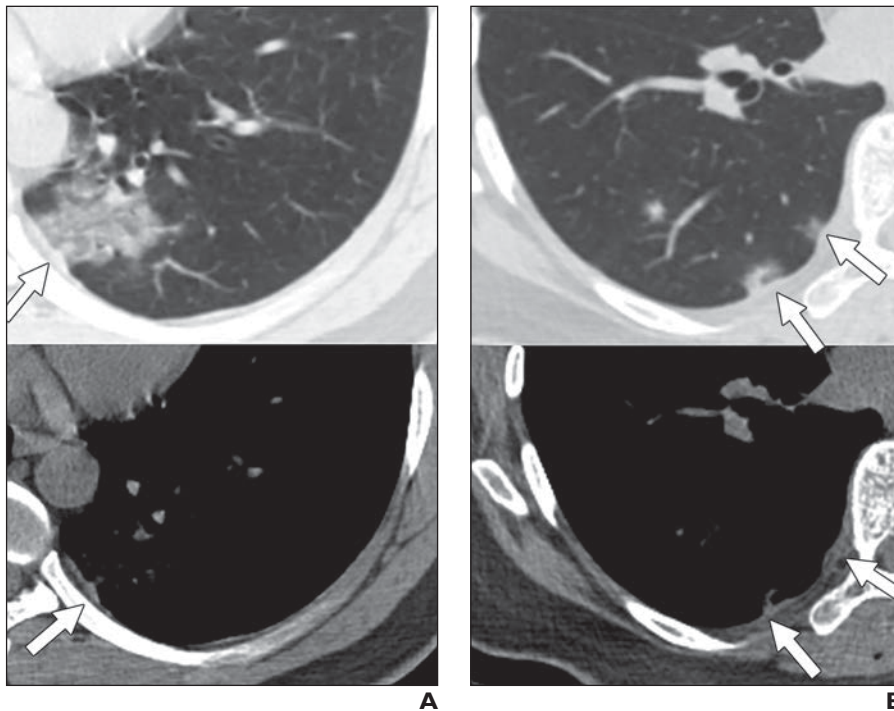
CT features indicating pleural changes caused by coronavirus disease 2019 pneumonia. Top images were obtained with lung window settings; bottom images were obtained with mediastinal window settings.
